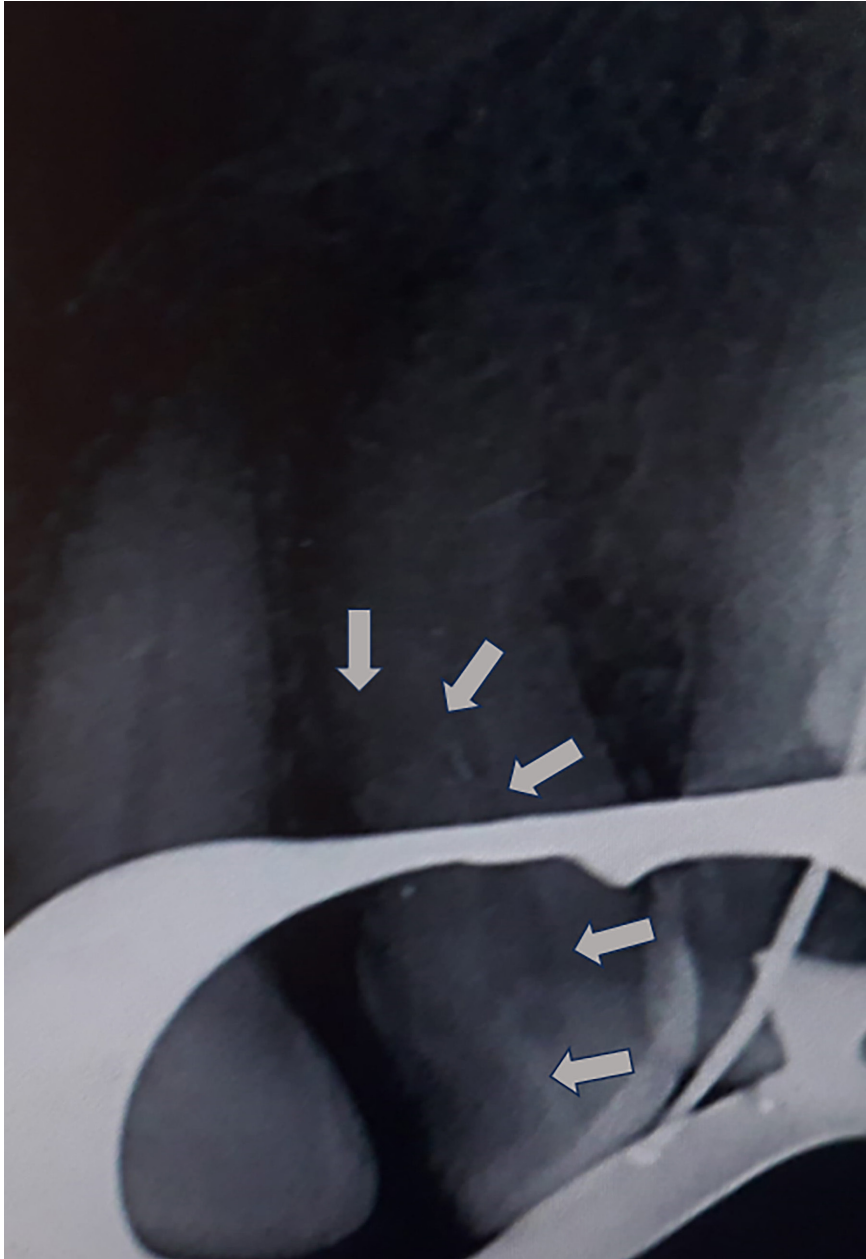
Pre op periapical X ray. Arrows pointing out radiolucency which indicates caries extending to the pulp
